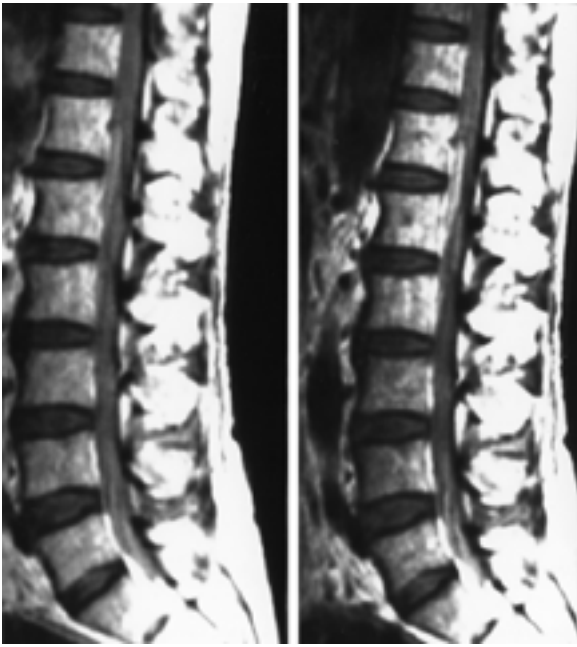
Left*: A noncontrast T₁-weighted sagittal MR image revealing a hyperintense mass in the subdural space at T-12 extending to L-5. *Right*: The mass enhanced slightly with intravenous administration of Gd.
